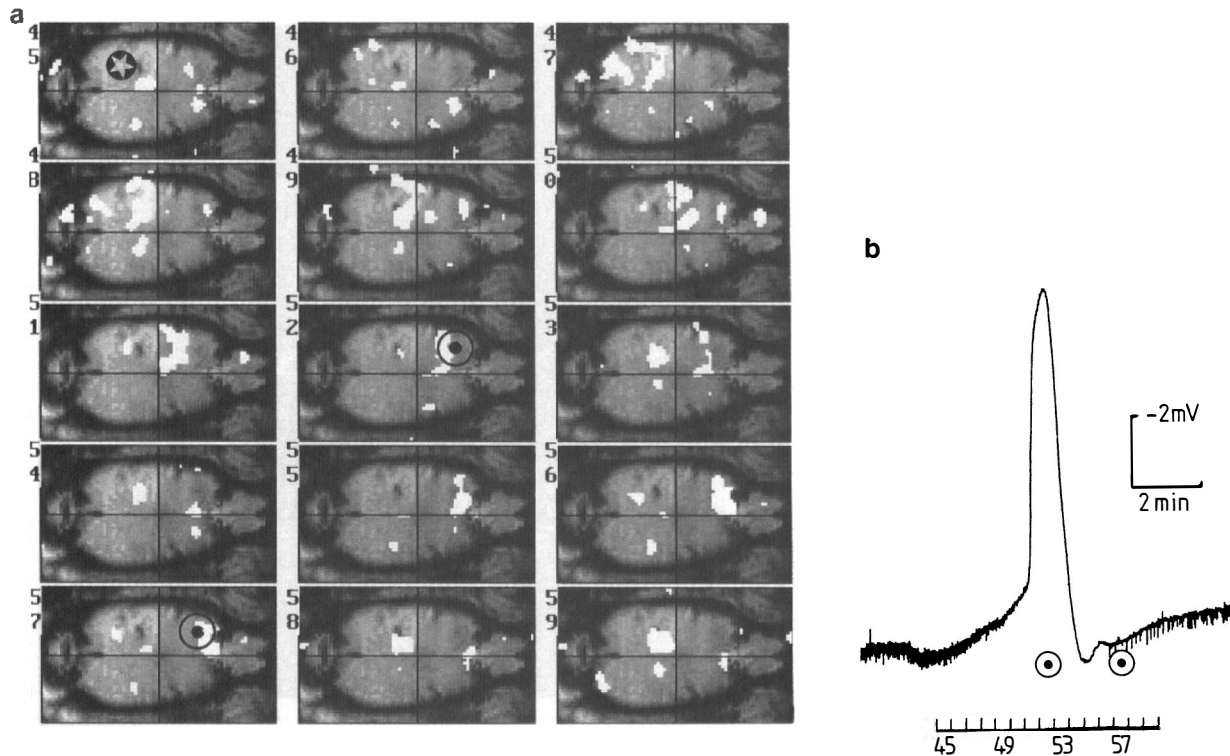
a: Threshold gradient echo MR images from a horizontal slice through the superficial cortex, superimposed on a high-resolution gradient echo image of the same slice. Images were acquired every 25 s. KCl was applied at the starred region during images 40–42, ~2 min before the start of the sequence shown. b: Voltage record shows SD recorded at the monitoring electrode. The approximate times at which the zone of enhanced MR signal reached and passed beyond the electrode site are shown by circled dots, and the site of the electrode is marked on the corresponding images by the same symbol. Signal-to-noise ratio was improved by smoothing images four times in time and three times in space with the kernel given for Fig. 2 and thresholding the second time derivative of the resulting sequence. Thresholds correspond approximately to a 2% signal increase. MR imaging parameters are as follow: TR, 90 ms; TE, 30 ms; 0.3-mm pixels; NEX, 2; 1-mm slice thickness; 128 phase-encoding steps; imaging time, 25 s per image.
